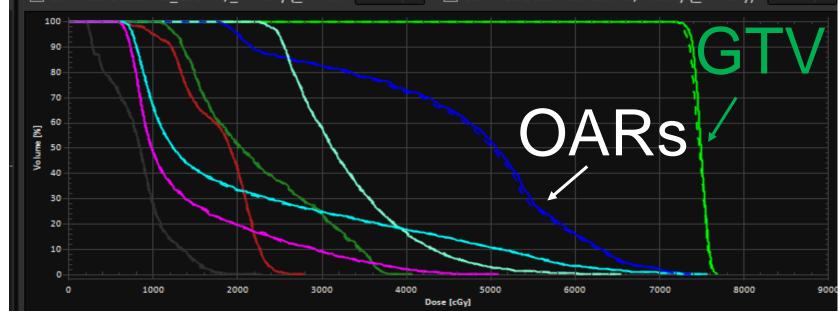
Right (magenta) and left (blue) parotid glands as seen on CBCT on the first day (day 1) (solid line) and last day (day 33) (dashed line) of treatment.
